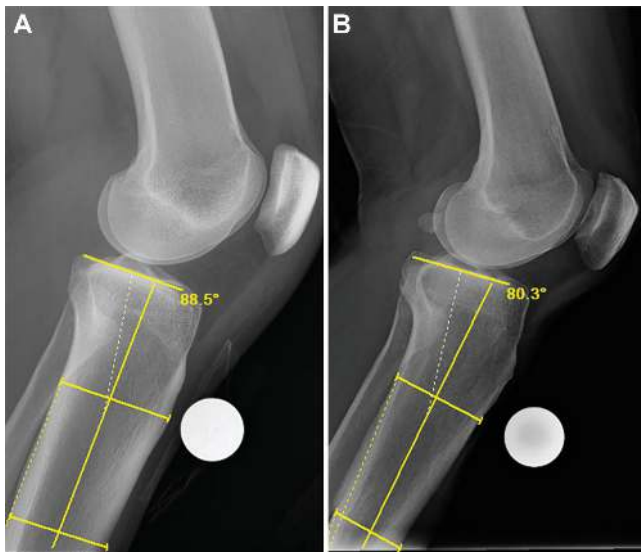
Tibial slope measurement comparison. (A) Left knee lateral radiograph of a patient with a posterior cruciate ligament (PCL) injury reveals a decreased posterior tibial slope measuring 1.5° as opposed to a (B) left knee lateral radiograph of a PCL-intact control with a normal posterior tibial slope measuring 9.7°. All controls were matched by age and sex to the patients with PCL injuries.
